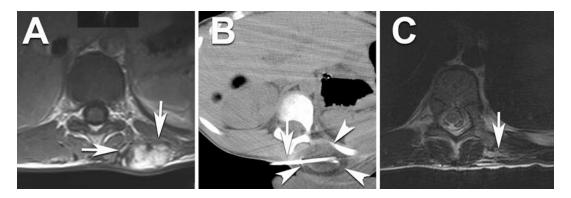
9-year-old female with a posterior chest wall extra-abdominal desmoid tumor previously treated with surgical resection and adjuvant chemotherapy. (a) Pretreatment T1-weighted, fat-suppressed gadolinium-enhanced image demonstrates a mass (*arrows*) in the left paraspinal musculature. (b) Prone non-contrast CT shows one of the two cryoprobes (*arrow*) with an ice
